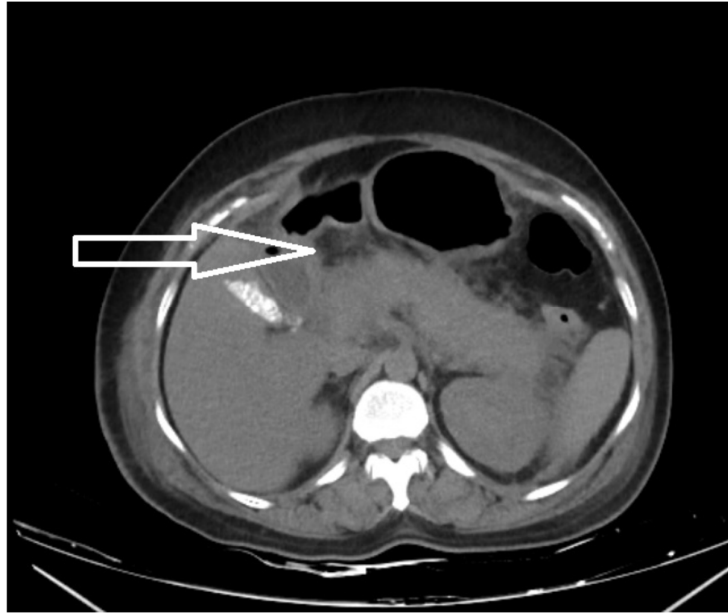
CT image shows a bulky pancreas with adjacent fat stranding (marked by the arrow).
